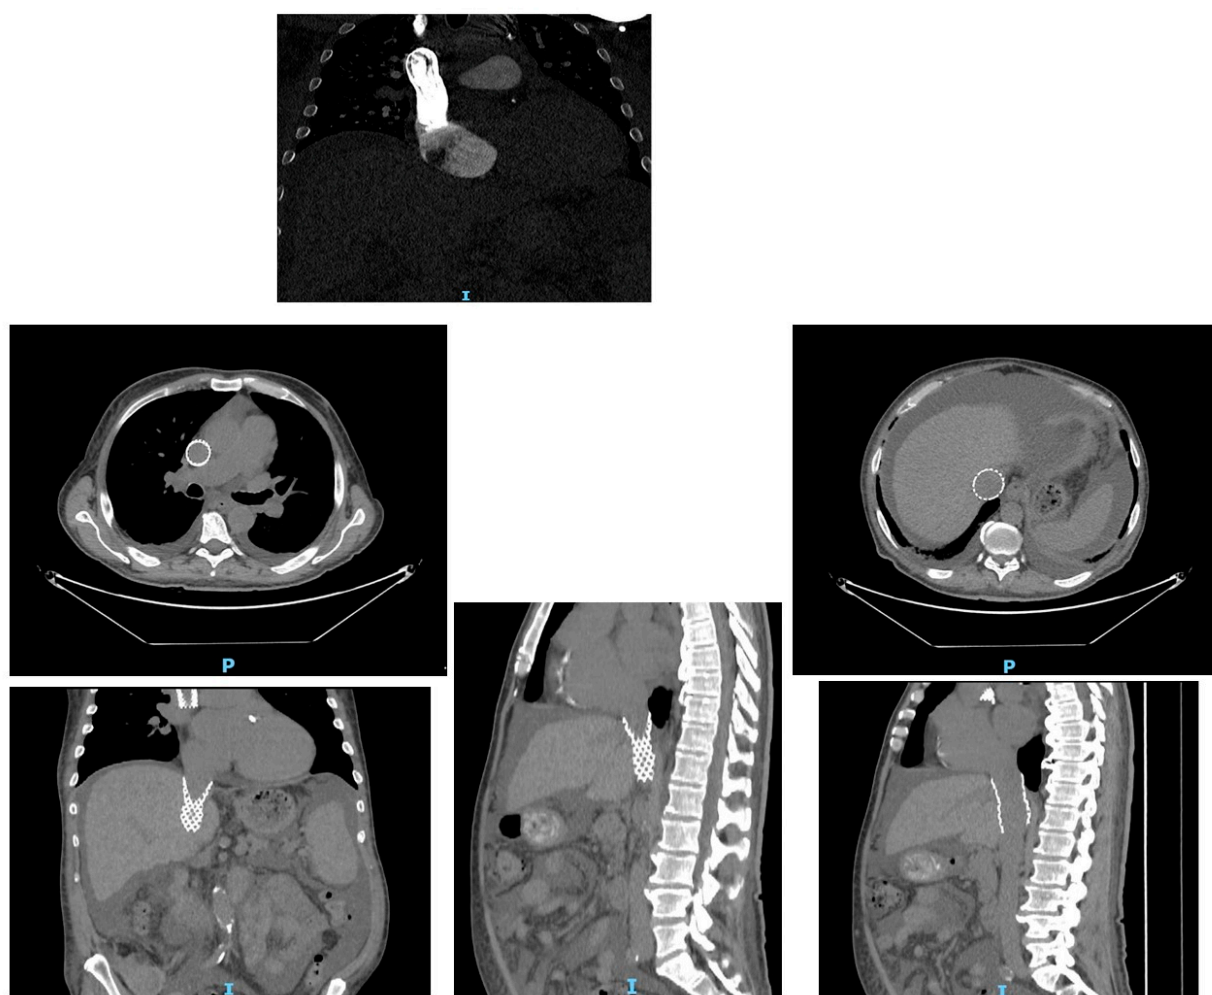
Control by computed tomography (also used by the physical medicine and rehabilitation specialist for co-evaluation of the spine) in Figures 11 and 12.
